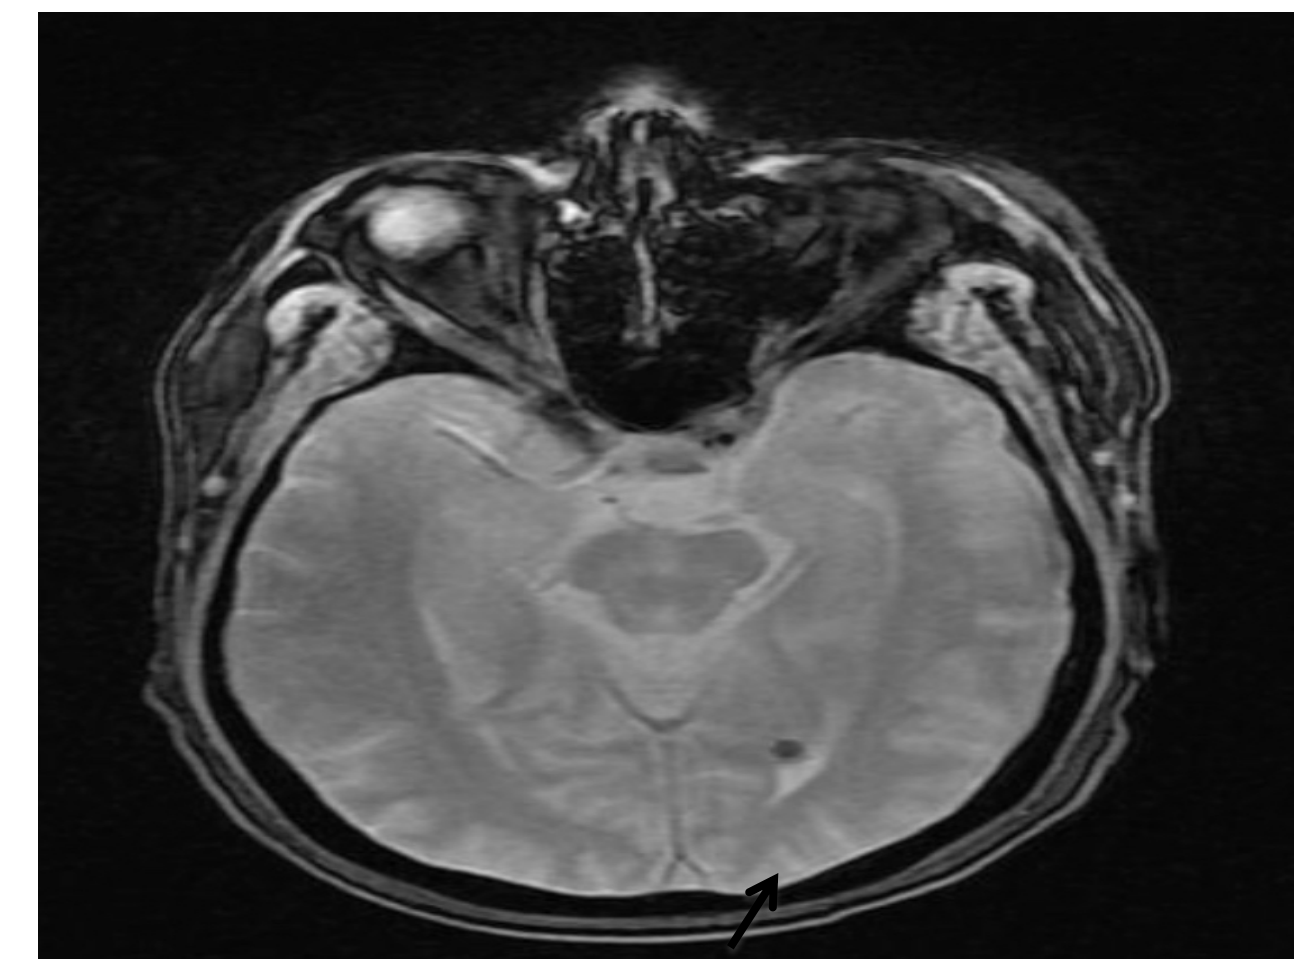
Non-contrast brain MRI with small hypointense foci
